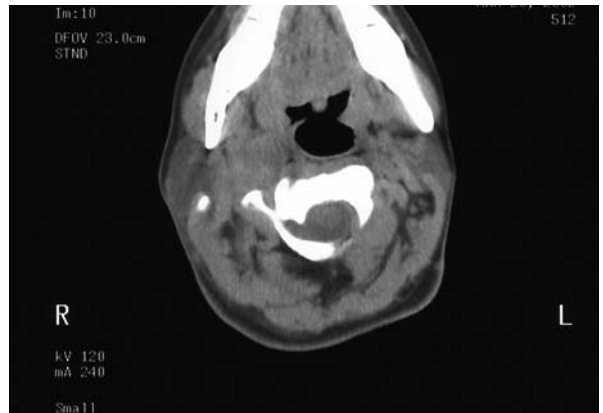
Postoperative CT findings. Stenosis of the hypopharyngeal cavity was improved.
